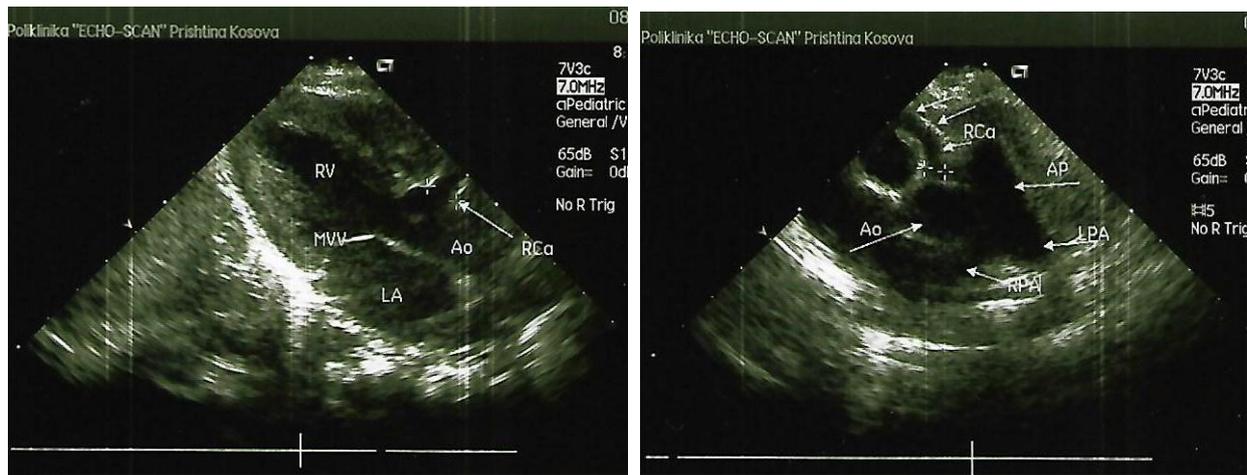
Transthoracic echocardiography presented dilated proximal part of the right coronary artery
